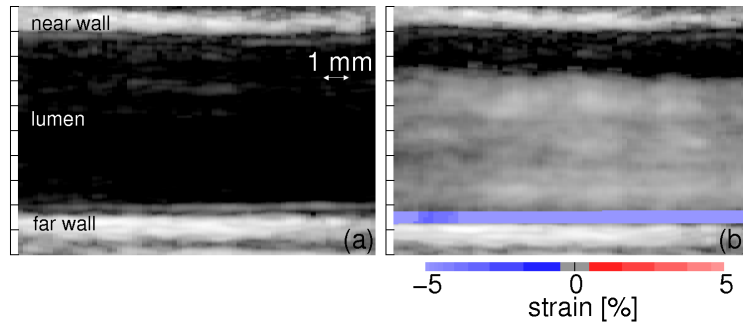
Ultrasonic images of the carotid artery of a 33-year-old male obtained at (a) the time of R-wave and (b) 0.15 s after R-wave.
